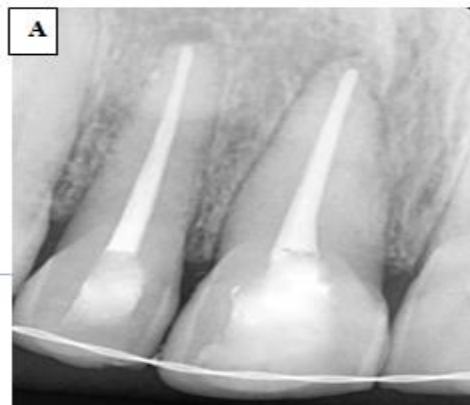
Radiographic image after endodontic treatment
